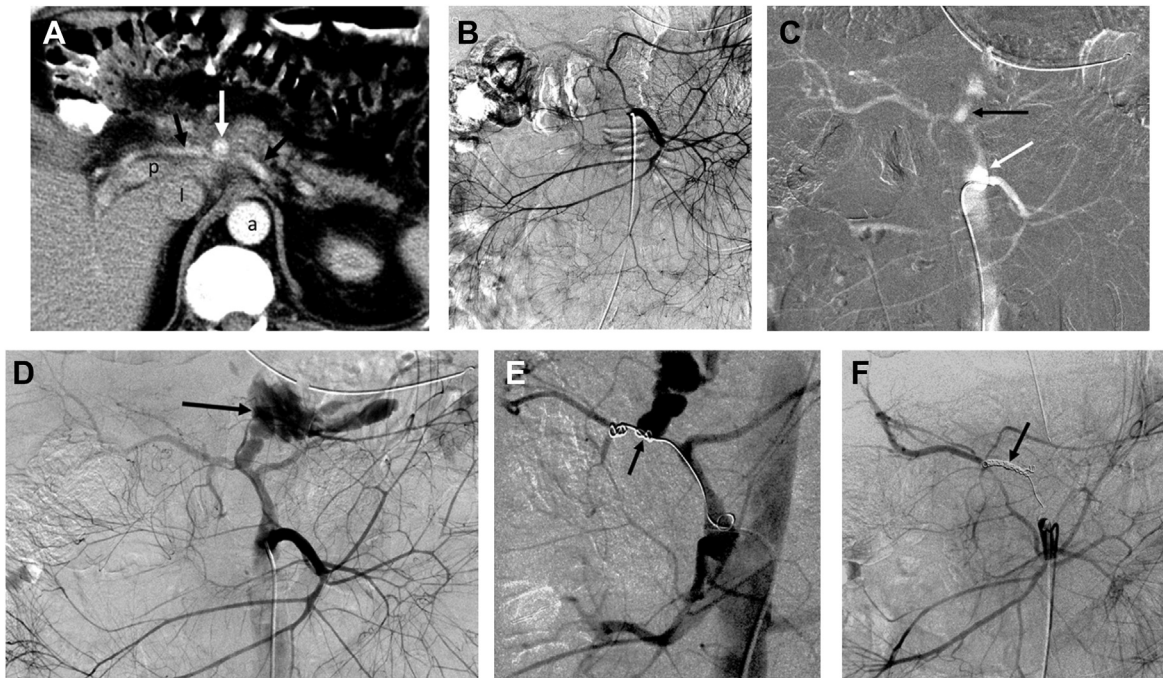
Ruptured common hepatic artery pseudoaneurysm with massive hematemesis in a 50-year-old man with a history of total gastrectomy with Roux-en-Y esophagojejunostomy for gastric adenocarcinoma. (A) Computed tomography section through the pancreas after intravenous injection of contrast material showing a 1.1-cm-diameter, hyperdense focus (white arrow) at the anterior aspect of the common hepatic artery (black arrows). (B) Digital subtraction superior mesenteric arteriogram (arterial phase) showing diffuse narrowing of the mesenteric artery branches secondary to hypovolemic hypotension. (C) CO₂ superior mesenteric arteriogram showing a celiacomesenteric trunk (white arrow) and extravasation from a common hepatic artery pseudoaneurysm (black arrow). (D) Repeat superior mesenteric arteriogram with the injection of contrast medium more proximally and at a higher injection rate showing filling of the celiac artery and massive extravasation from the common hepatic artery pseudoaneurysm into the Roux-en-Y loop and then into the esophagus (arrow). (E) After deployment of a 6 mm × 14 cm Nester coil in the common hepatic artery distal and proximal to the pseudoaneurysm using a 3F Renegade STC microcatheter, arteriogram shows persistent extravasation. The proximal part of the coil was inadvertently deployed into the celiac axis. Prior to deployment of a second coil, the patient developed cardiac arrest. Two minutes after a termination of unsuccessful chest compression that had lasted 30 minutes, the patient's spontaneous cardiopulmonary circulation returned. (F) Deployment of additional Tornado microcoils in the common hepatic artery resulted in occlusion of the common hepatic artery and pseudoaneurysm with arrest of the bleeding (arrow). The hepatic artery reconstitutes through the pancreatic arcade arteries from the superior mesenteric artery. a, aorta; l, inferior vena cava; p, portal vein.
